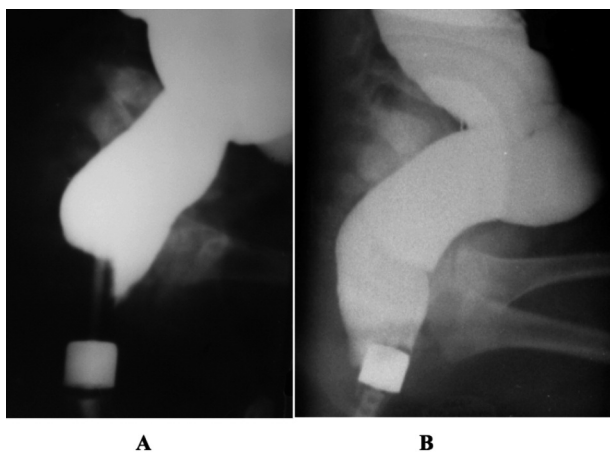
The lateral radiographs of children first year of life during barium enema were made. Metal marker 1.6 cm diameter is located near the anus.
